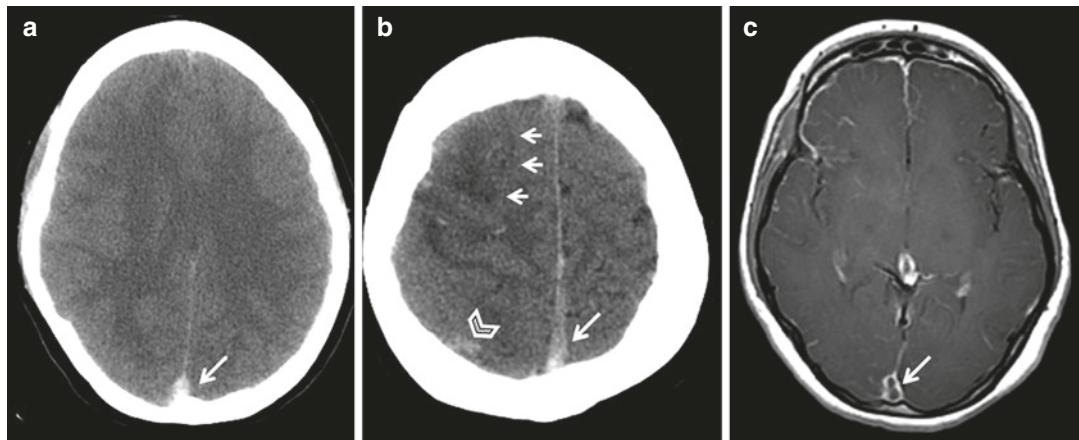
20-year-old man with new seizures in the context of progressive headache without focal deficit. Axial non-contrast head CT images (a, b) show increased density along the posterior aspect of the superior sagittal sinus (arrows) suggestive of thrombus, loss of gray-white matter differentiation in the right frontal lobe (small
